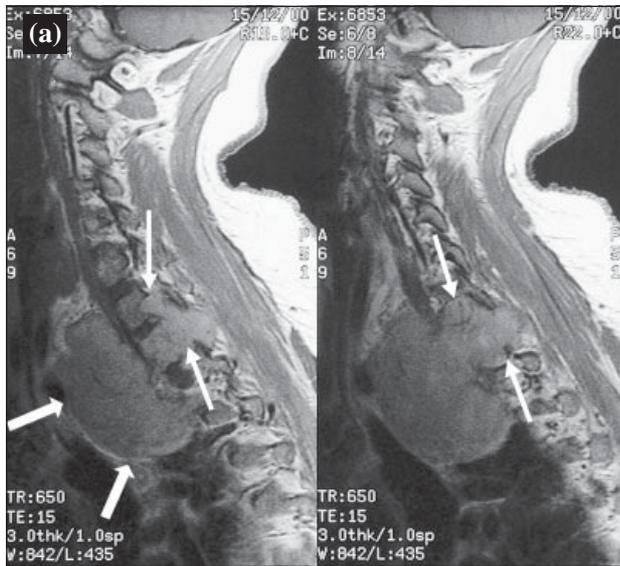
Magnetic resonance imaging scan of the lesion. (a) Sagittal T1-weighted image shows a lobulated soft tissue mass with foramen involvement (thin arrows) and a large anterior component (thick arrows); (b) coronal T1-weighted image showing a right apical soft tissue mass with bony involvement.
